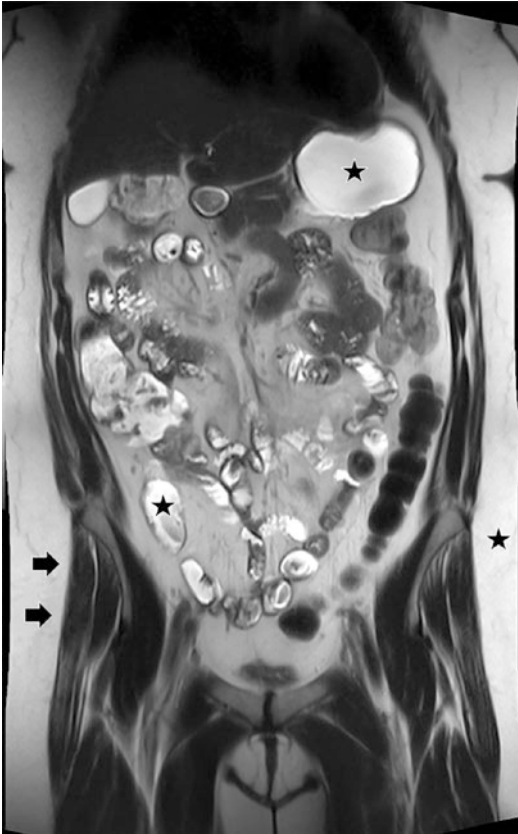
T2-weighted coronal survey view of the abdomen. Note the hyperintense (bright) signal of subcutaneous fat as well as that of fluid within the stomach and bowel (stars). Abdominal wall and lower extremity musculature are relatively hypointense (dark, arrows)
